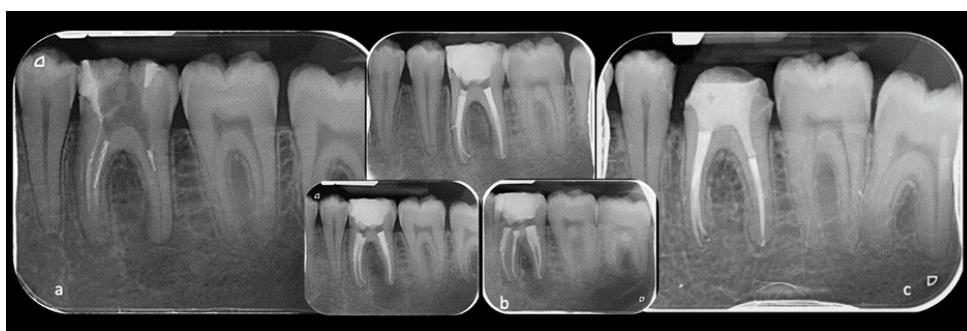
a) Pre-operative x-ray; b) Post-operative x-ray (mesial and distal shifts highlighting conserved root anatomy); c) 5-year follow-up.
